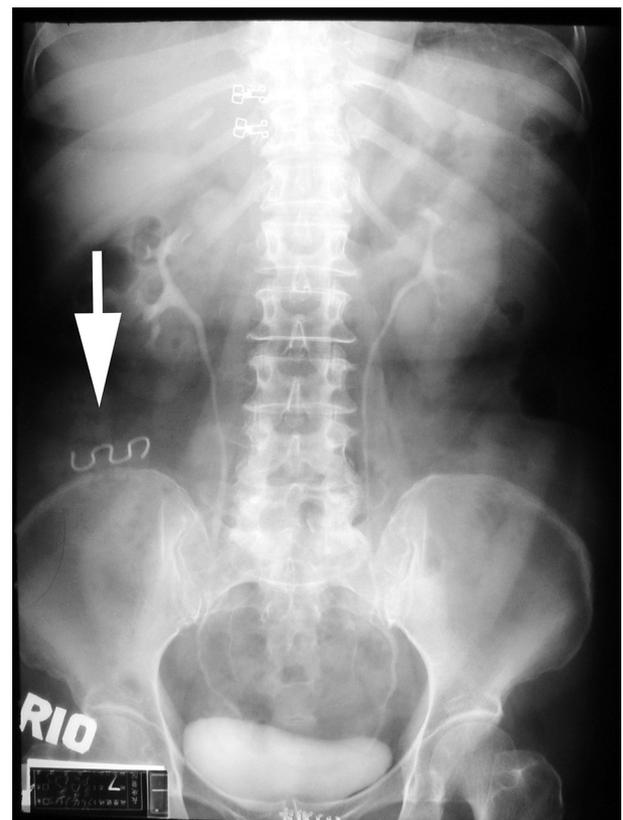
Abdominopelvic radiograph showed wandering IUD at right lower abdominal cavity, outside the pelvis.
